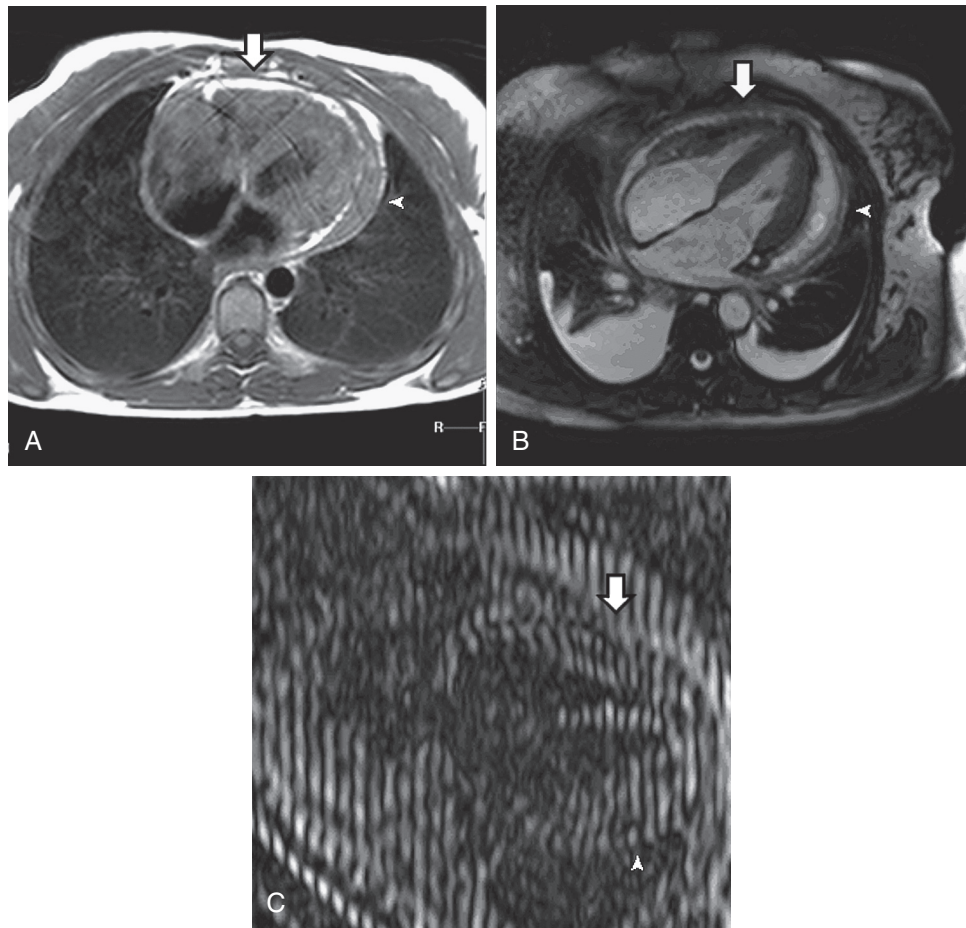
■ Effusive-constrictive pericarditis. Axial dual-inversion T1-weighted (A) and cine steady-state free-precession (B) cardiovascular magnetic resonance images of a patient with effusive-constrictive pericarditis. Pericardial fluid appears relatively bright; pericardium and organized material appear dark. The end-systolic tagged four-chamber image (C) demonstrates tethering of pericardial elements to the right ventricular (*arrow*) and left ventricular (*arrowhead*) walls.
